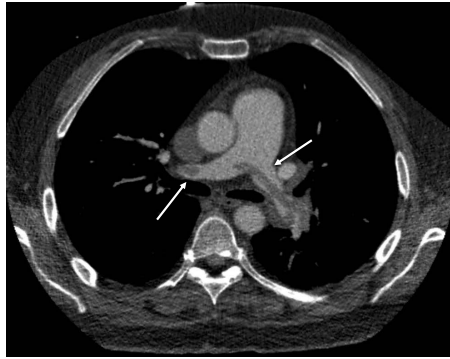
Computed tomography pulmonary angiography (CTPA) of patient with saddle embolus. Large central pulmonary emboli are well recognizable by CTPA.
